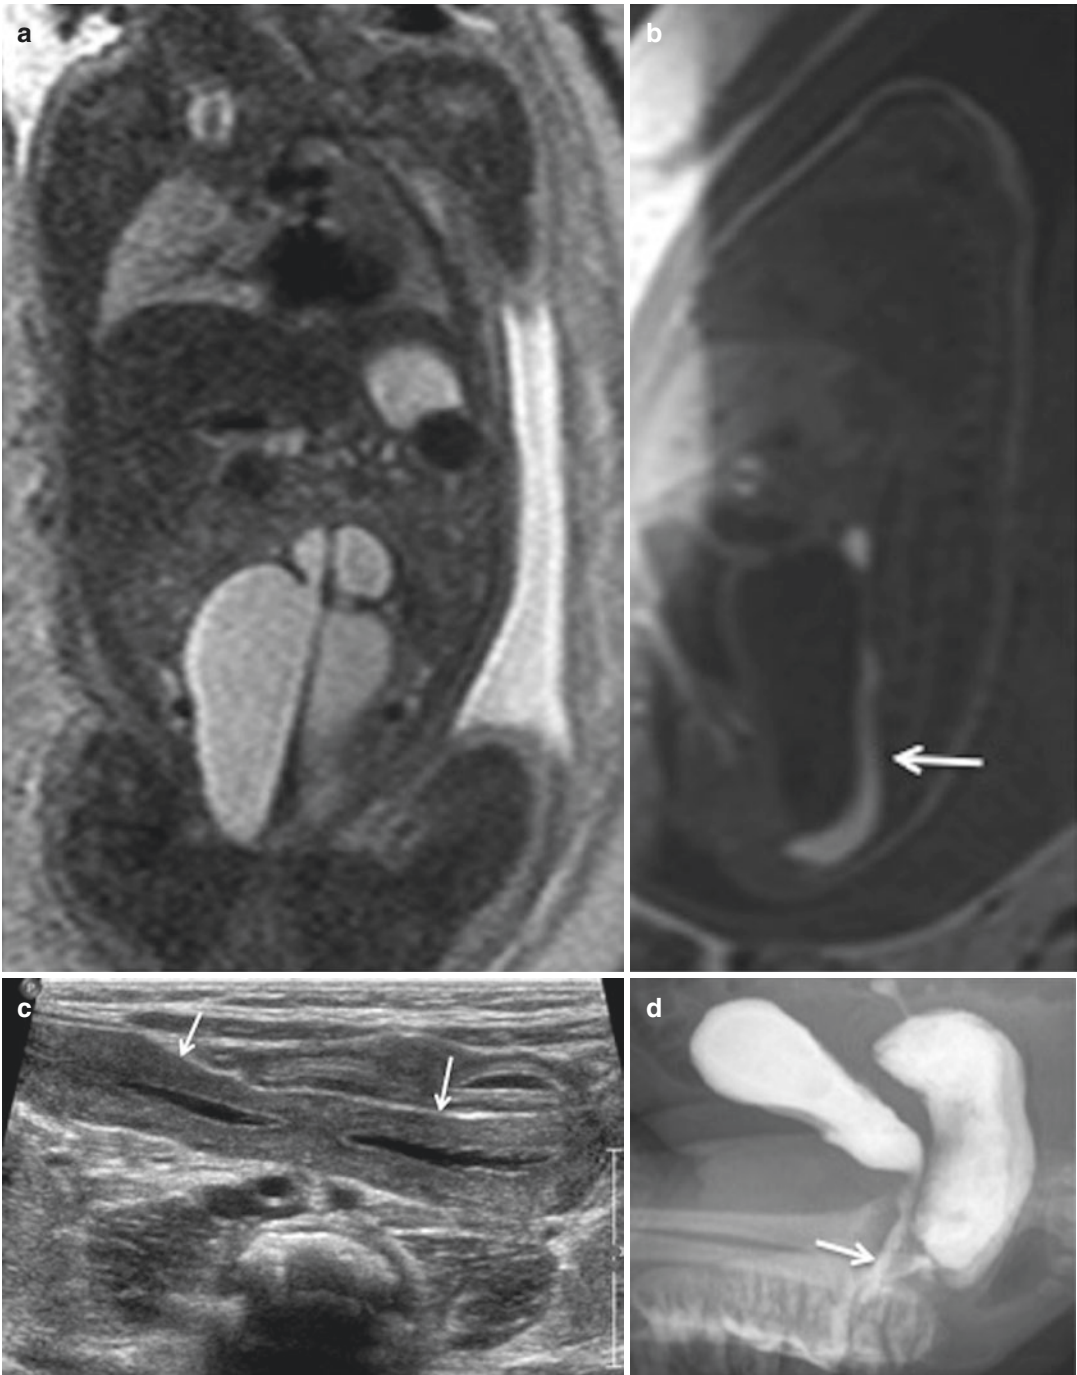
Urogenital sinus. (a) Fetal MR imaging: coronal T2 weighted image performed at 33 weeks to evaluate a cystic pelvic mass seen at obstetrical US. The “mass” appears septated and corresponds to a duplicated genital tract distended by fluid suggesting a complex malformation with a urogenital fistula. (b) Sagittal T1 weighted
